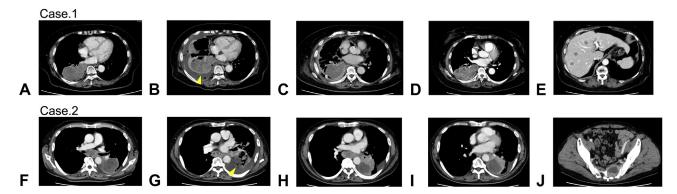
Enhanced chest CT images. Case 1: (A) Before induction of immunochemotherapy, a 100-mm mass was found, located just below the right pleura. (B) On day 7, there was an emergence of right pleural effusion. The yellow arrowhead indicates rupture of the tumor wall and pleura. (C) After insertion of the chest drainage tube, there was (D) slight shrinkage of the lung primary tumor, and (E) emergence of multiple liver metastases during the treatment for empyema. Case 2: (F) before induction of immunochemotherapy, a 77-mm mass was seen located just below the right pleura. (G) On day 14, there was an emergence of a left pleural effusion. The yellow arrowhead indicates rupture of the tumor wall and pleura. (H) After the treatment for pleuritis, there was a slight shrinkage of the lung primary tumor. (I) During the treatment for pleuritis, the lung tumor enlarged, and (J) a new bone metastasis emerged in the patient's sacrum. CT, computed tomography.
